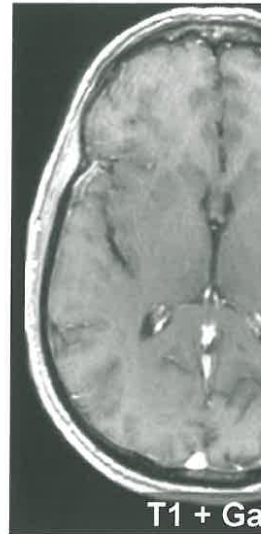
Intravascular Stasis in left MCA infarction. Mild sulcal effacement is evident on T1. As seen here, FLAIR hyperintensity and sulcal enhancement is typically seen on
